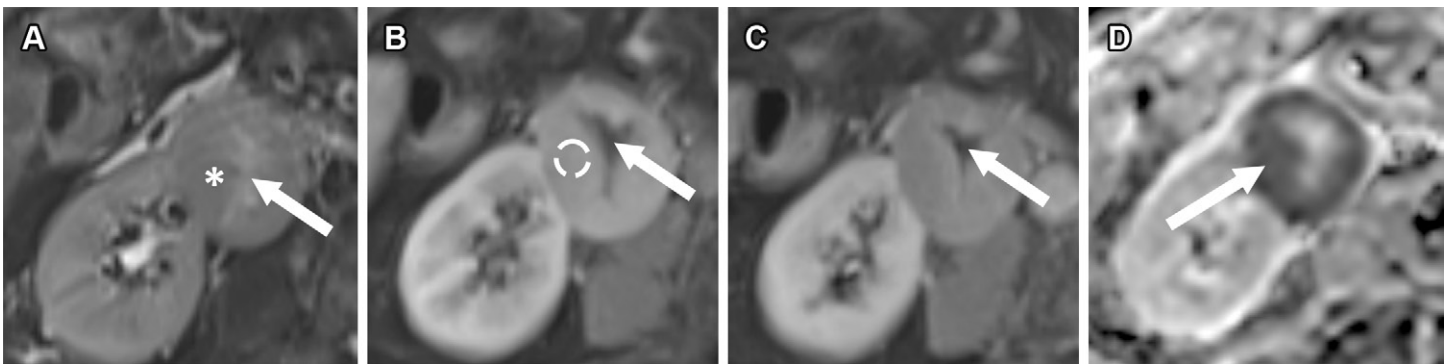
chrCC incidentally found at US in a 78-year-old man with incomplete bladder emptying. (A) Axial T2-weighted fat-suppressed MR image shows predominant T2 isointensity (arrow) within a 3.8-cm right renal mass (*). (B) Axial postcontrast CMP T1-weighted MR image shows intense enhancement (arrow) of the mass (75% mass-to-cortex ratio), which was measured in the most enhancing portion (dashed circle). (C) Axial postcontrast delayed phase T1-weighted MR image shows no segmental enhancement inversion. A nonenhancing central scar (arrow) is present, suggesting oncocytoma as a possible differential diagnosis. (D) Axial ADC map shows marked diffusion (arrow) restriction of the mass. The ccLS is 4 (likely ccRCC) with a differential diagnosis of chrRCC, particularly given the marked diffusion restriction. Biopsy revealed a grade 2 chrRCC.
